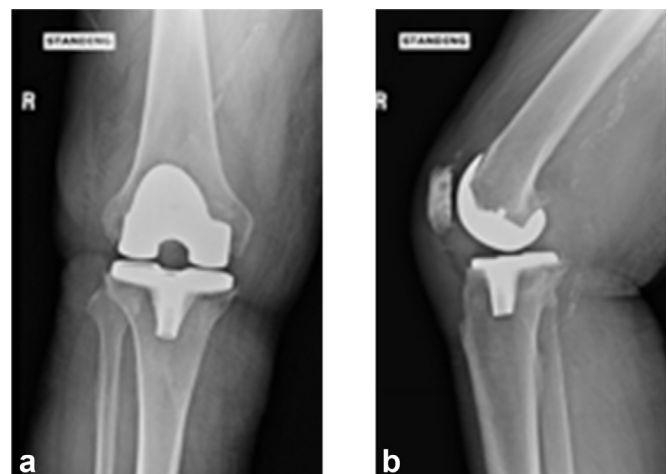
(a) and (b). AP and lateral radiograph of TKA at presentation in case 2. TKA, total knee arthroplasty.
